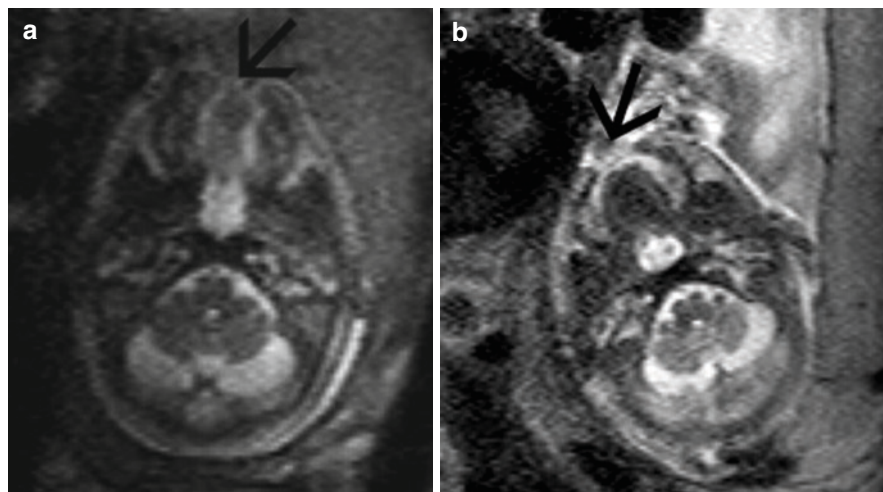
T2 weighted sagittal MRI image of a complete cleft of the primary and secondary palate missing the hypointense layer of the hard palate at 20 (a) and 22 (b) weeks gestational age
